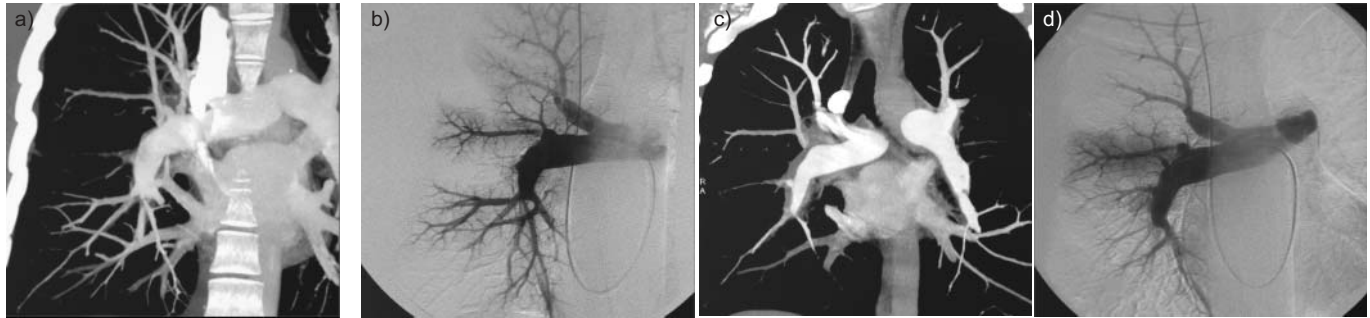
Case 6. a) Computed tomography pulmonary angiography and b) formal pulmonary angiography confirmed the presence of chronic thromboembolic disease. c) and d) Progressive occlusive vasculopathy was noted on repeat imaging studies.
